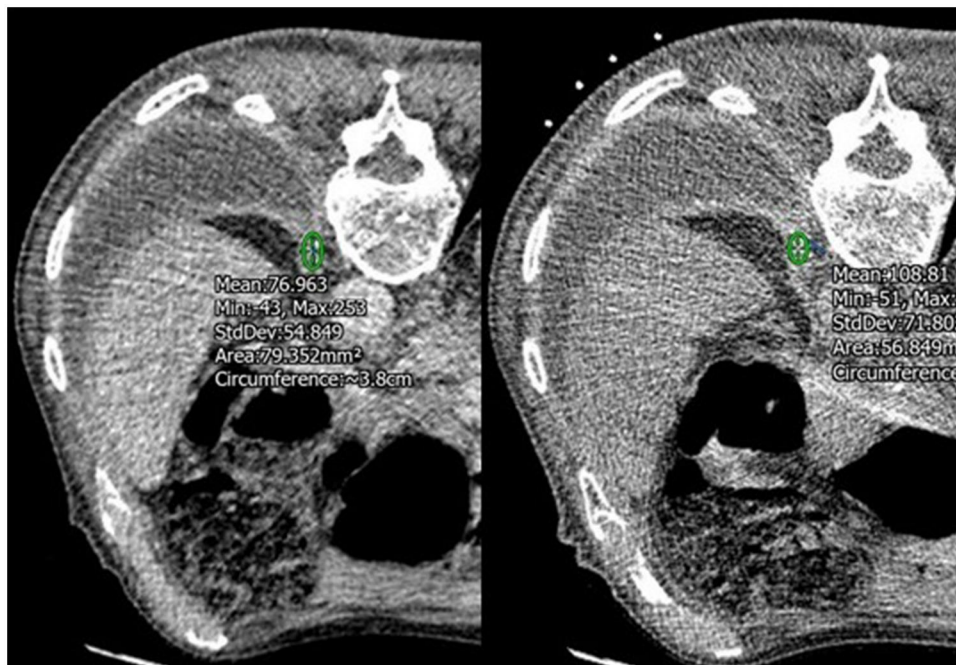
Left-sided mesothelioma, diagnosed via CT-guided pleural biopsy. The planning CT (left) was obtained in the venous phase. The right hand image shows the first image as part of the biopsy, at approximately 5 minutes after contrast. The pleura has continued to enhance.
